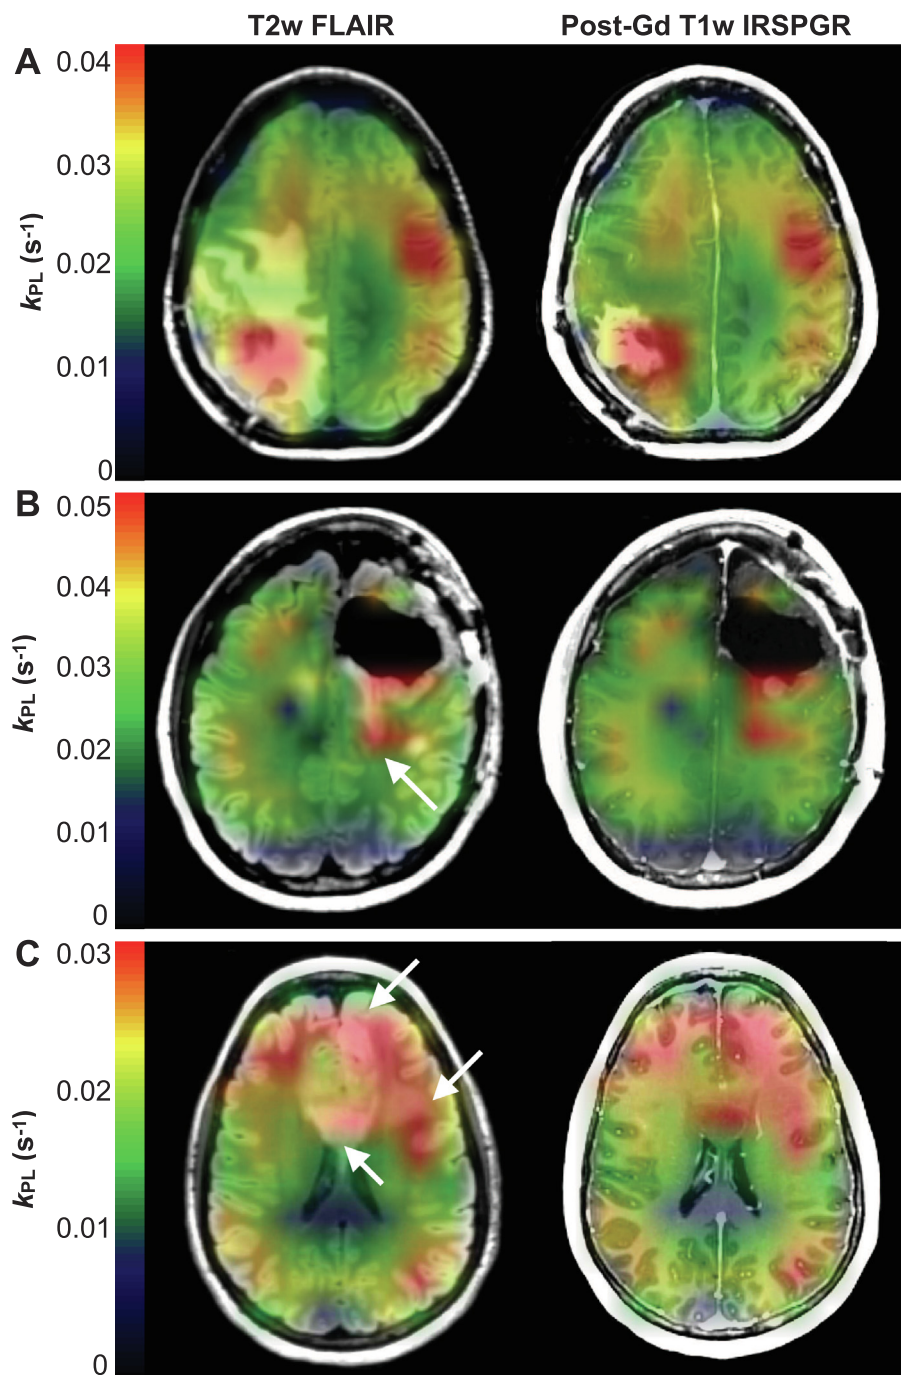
Profiles of progression. Imaging at the time of radiologically-defined progression shown using k_{PL} maps overlaid on T_2 -weighted FLAIR and post-gadolinium T_1 -weighted images. Patient P5 demonstrated elevated k_{PL} in the lesion that was spatially heterogeneous, with higher values in and around the CEL compared to the surrounding T2L (A); whereas patient P2 showed uniformly elevated k_{PL} that extended distally from the CEL into the T2L, as indicated by the white arrow (B). Diffusely elevated k_{PL} in patient P4 corresponded with a large non-enhancing T2L centered in the corpus callosum and extending to the left frontal white matter and cortex (white arrows) (C). In each case, the lesion k_{PL} highlighted radiological progression.
